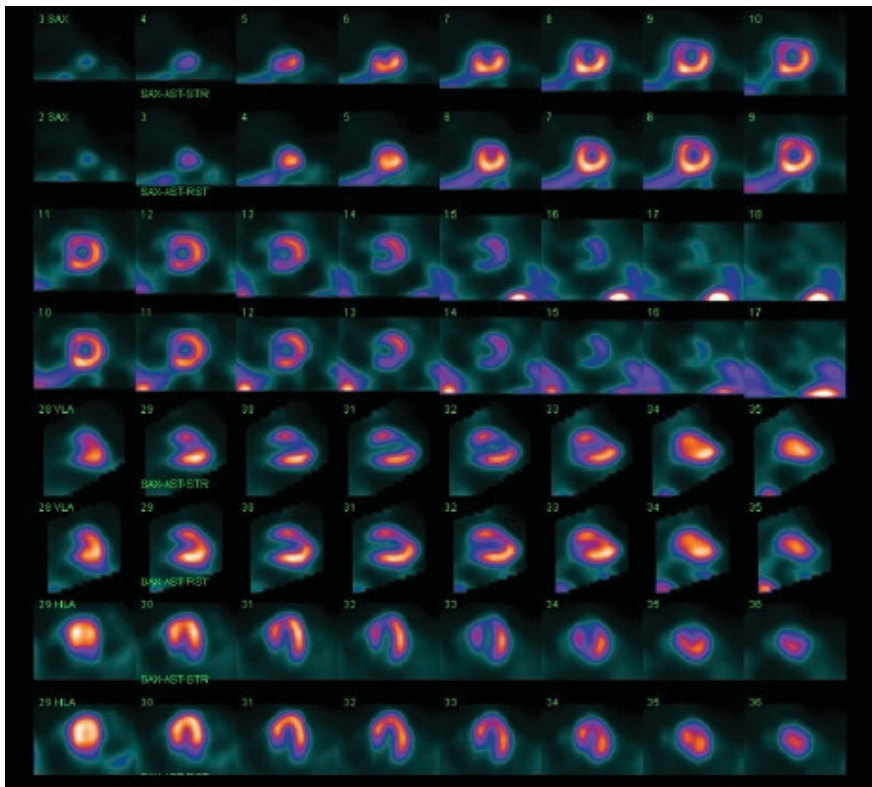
SPECT MPI showing a large severe mid-to-distal anterior wall and apical stress perfusion defect that shows reversibility at rest. Subsequent cardiac catheterization showed high-grade (approximately 90%) stenosis in the left anterior descending artery proximal to a previously placed stent.
